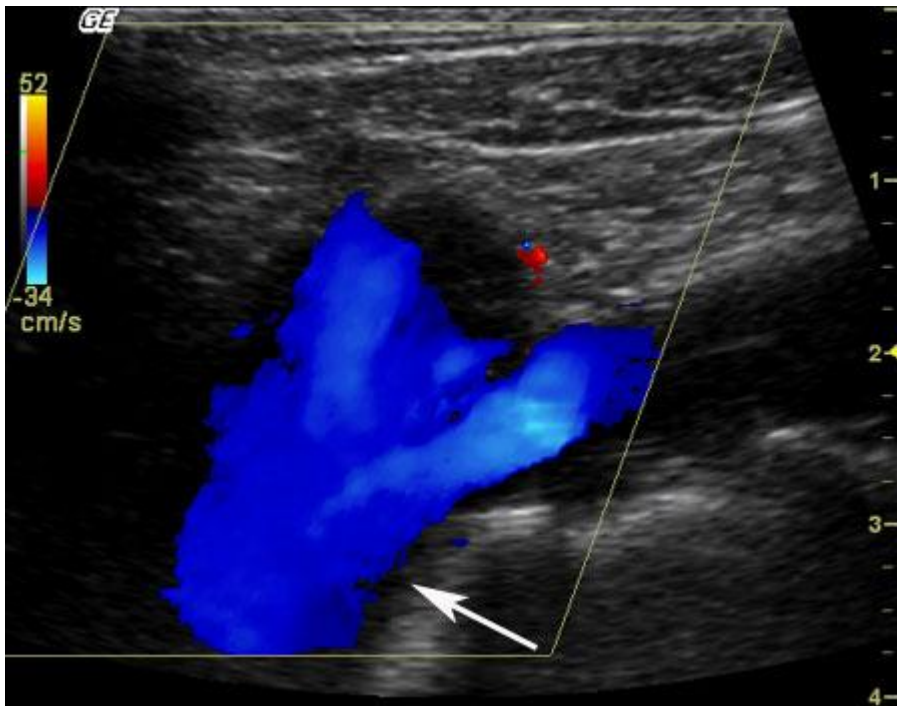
Color Doppler imaging is, however, very useful in evaluating the brachiocephalic junction (arrow), confirming the absence of localized thrombus. Care must be given to adjust the gain of the Doppler settings since the color Doppler signals can paint over relatively echolucent (hypoechoic) thrombus.
